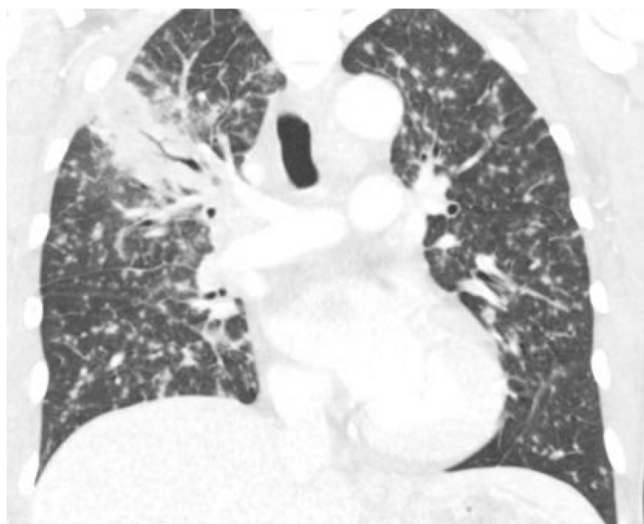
Admission CT scan of the chest, coronal view.
